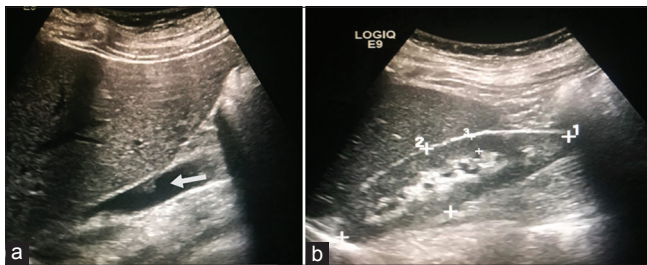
(a and b) Abdominal ultrasound right after pharmacomechanical thrombolysis showed significant reduction of the inferior vena cava thrombus, see arrow. There is also marked reduction of the right kidney congestion, see arrow
